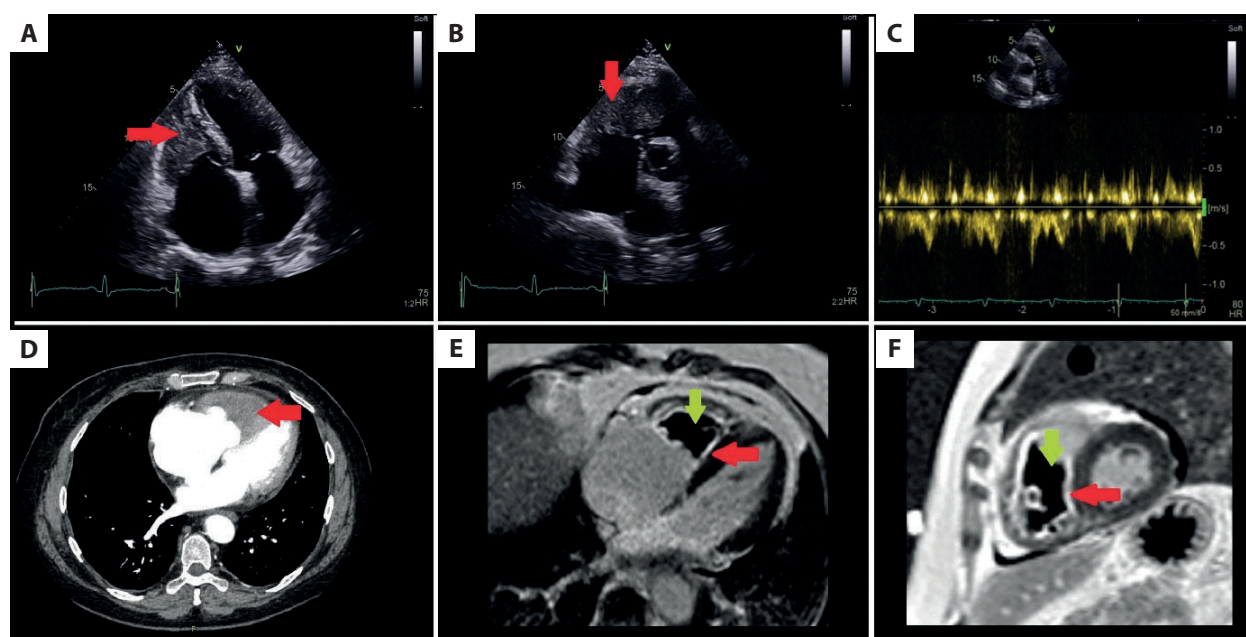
A–C. Transthoracic echocardiography: A. Apical 4-chamber view. B. Parasternal short axis view: the presence of a large mass filling almost completely the right ventricular cavity and right ventricular outflow tract (the red arrows). C. Parasternal short axis, the pulsed wave Doppler technique: abnormal spectrum of the pulmonary flow with atypical notching. D. Computed tomography angiogram: a lack of post-contrast enhancement in the right ventricle. E, F. Cardiac magnetic resonance: E. 4-chamber view. F. Short axis mid-ventricular view. Late gadolinium enhancement. A giant heterogenic mass filling the right ventricular cavity (the green arrows). The global subendocardial fibrosis of the right ventricle (the red arrows)
